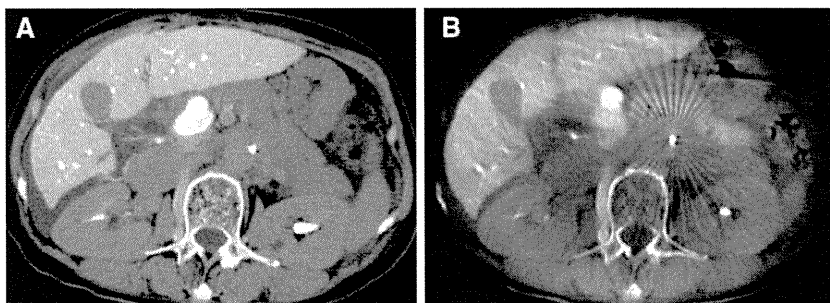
A 71-year-old woman with HCC. A Conventional CTAP image shows a hypoattenuating mass in the right lobe of the liver. B CBCTAP image clearly shows the hypoattenuating mass. However, strong image artifacts from a catheter placed in the superior mesenteric artery are also seen.
